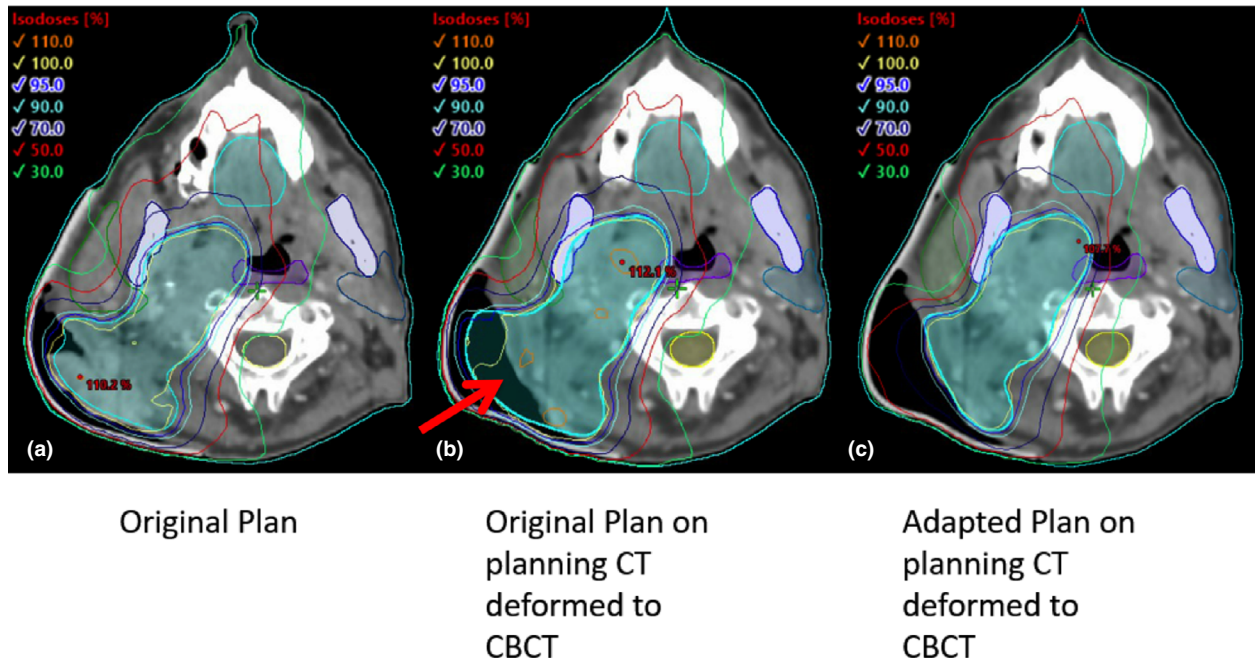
Axial view of original planning CT shown with original planning target volume (A), the planning CT deformed to the CBCT taken on the 10th fraction of treatment, with the original plan recalculated (B), the planning CT deformed to the CBCT taken on the 10th fraction with the replan calculated.
